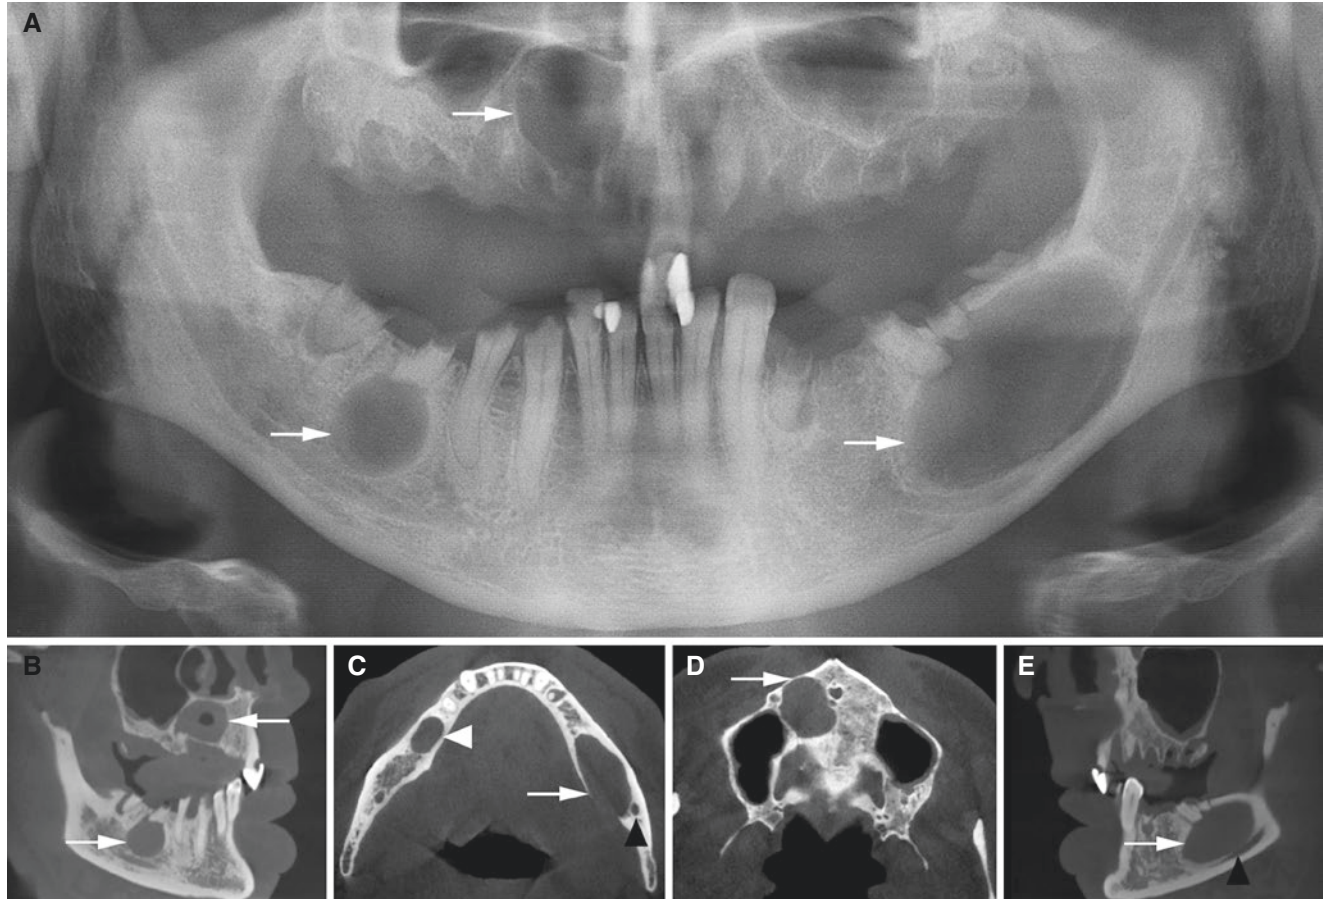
Radicular (residual) cysts, mandible, maxilla; 45-year-old male with variable pain from the upper and lower jaw. (A) Panoramic view shows well-defined round or oval corticated radiolucencies: one residual cyst in the maxilla and two periapical cysts in the mandible (arrows). Several roots are remaining in the mandible, and many have recently been extracted in the maxilla. (B) Oblique sagittal view shows cysts in the right mandible and right maxilla (arrows) and in the mandible with direct contact with root apex. (C) Axial CBCT image shows
